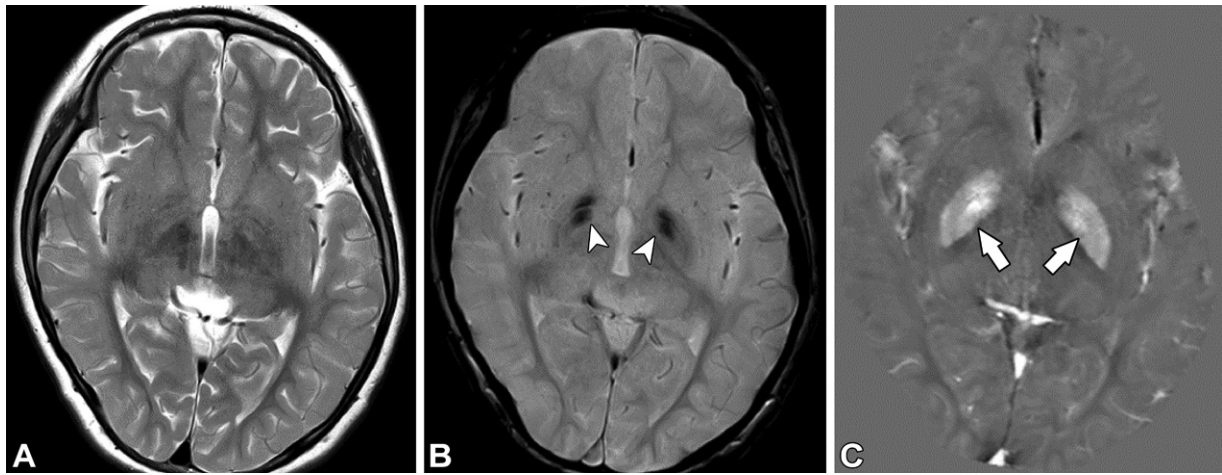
NBIA 5 in an 8-year-old boy. (A) Axial T2*-weighted MR image shows no abnormality around the basal ganglia. (B) Axial T2*-weighted MR image shows focal hypointensity in the anterior part of the globus pallidus (arrowheads). (C) QSM image clearly demonstrates high contrast in the entire bilateral globus pallidus (arrows), suggesting abnormal iron deposition compared with that in healthy patients of the same age (see Fig 6).
